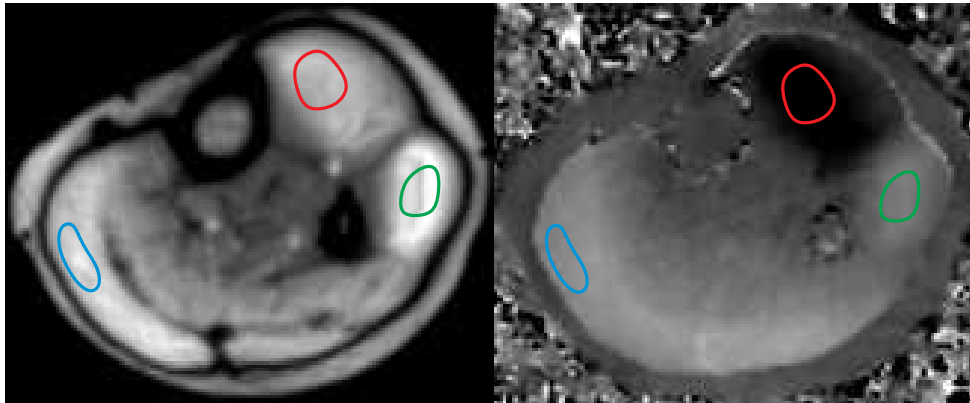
Magnitude image (left) and phase-contrast map (right) depicting the skeletal muscle motion using real-time PC MRI. Region of interests include gastrocnemius-medial (blue), tibialis anterior (red) and fibularis longus (green) of the lower limb.
